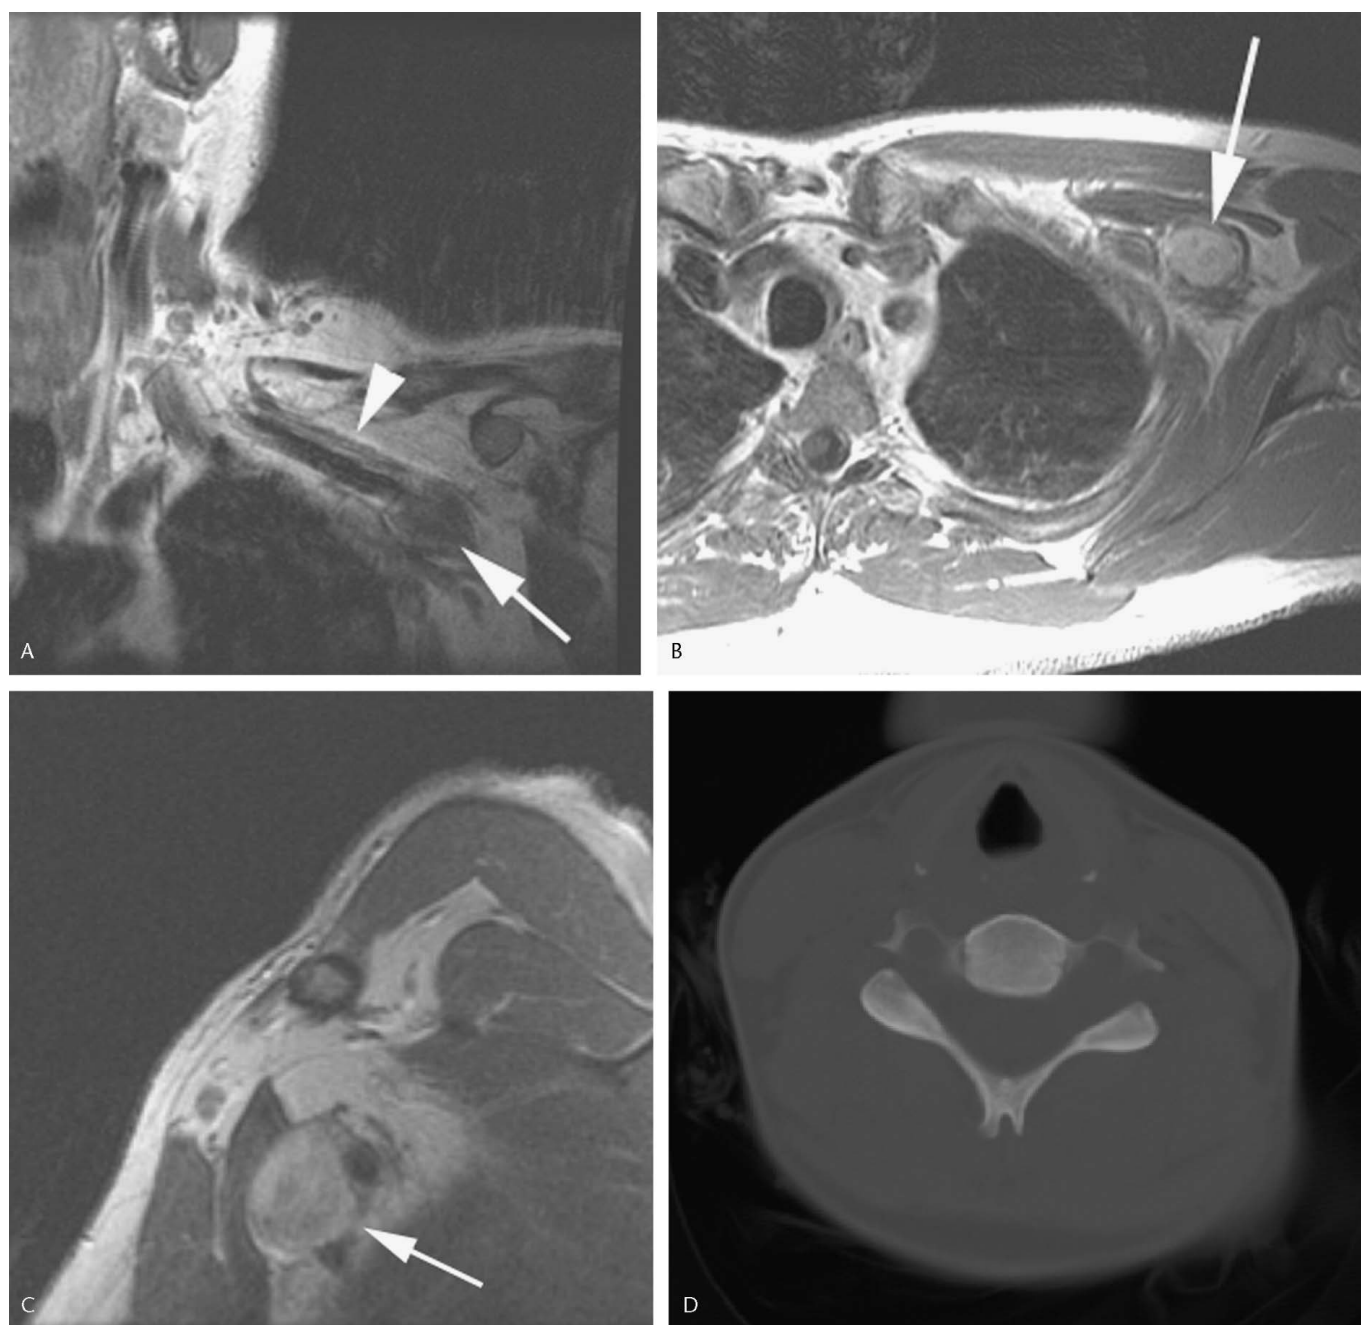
Schwannoma in two patients. A, Coronal precontrast T1-weighted image shows tumor (arrow) adjacent to the brachial plexus cords (arrowhead). B, Axial postcontrast T1-weighted image shows enhancement of same mass. C, Sagittal postcontrast T1-weighted image shows enhancement of same mass. D, Axial CT image of another patient shows expansion of the left neural foramina by schwannoma.
